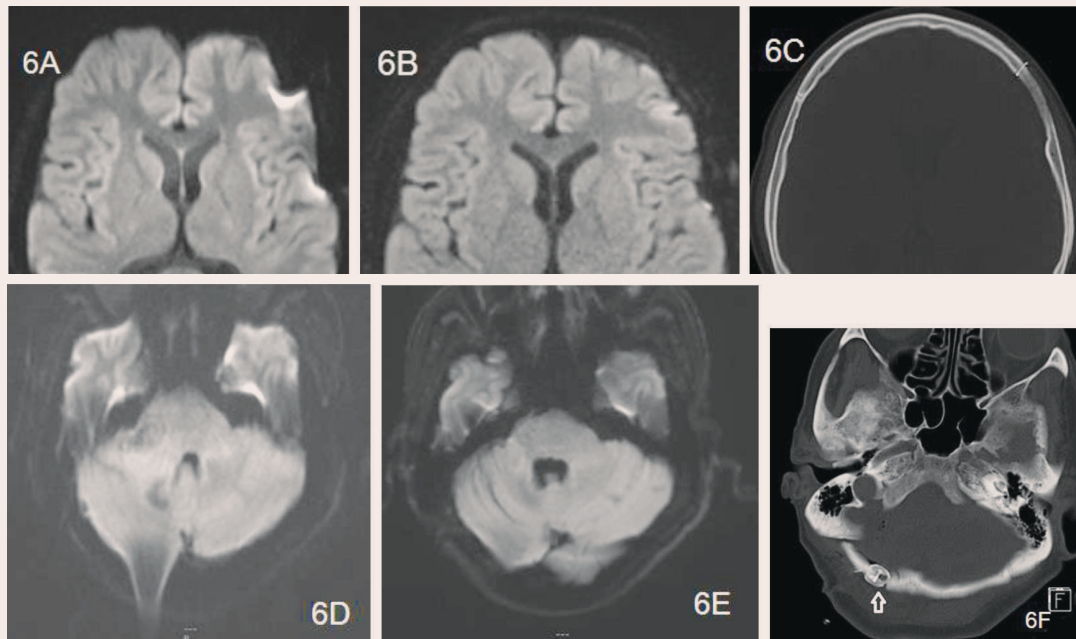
Direct comparison of signal loss, bright pile-up artifact and image distortion: at the left frontal lobe between SS-EPI (6A) and RS-EPI (6B) with effect by metallic devices in CT (6C), at the right occipital lobe between SS-EPI (6D) and RS-EPI (6E) with effect by metallic devices in CT (6F).
